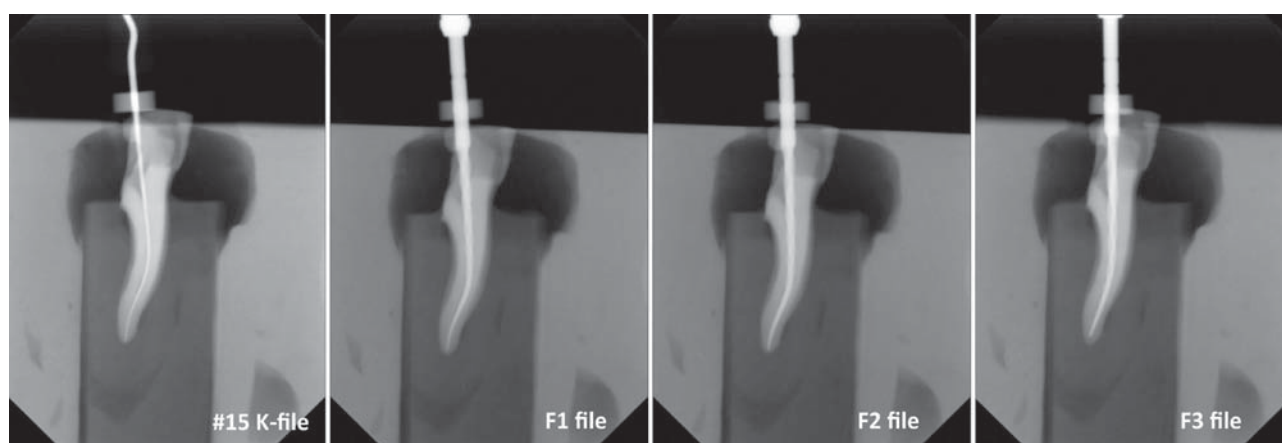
Left to right, standardized radiographic images obtained with #15 K-file (baseline), and F1, F2 and F3 files
